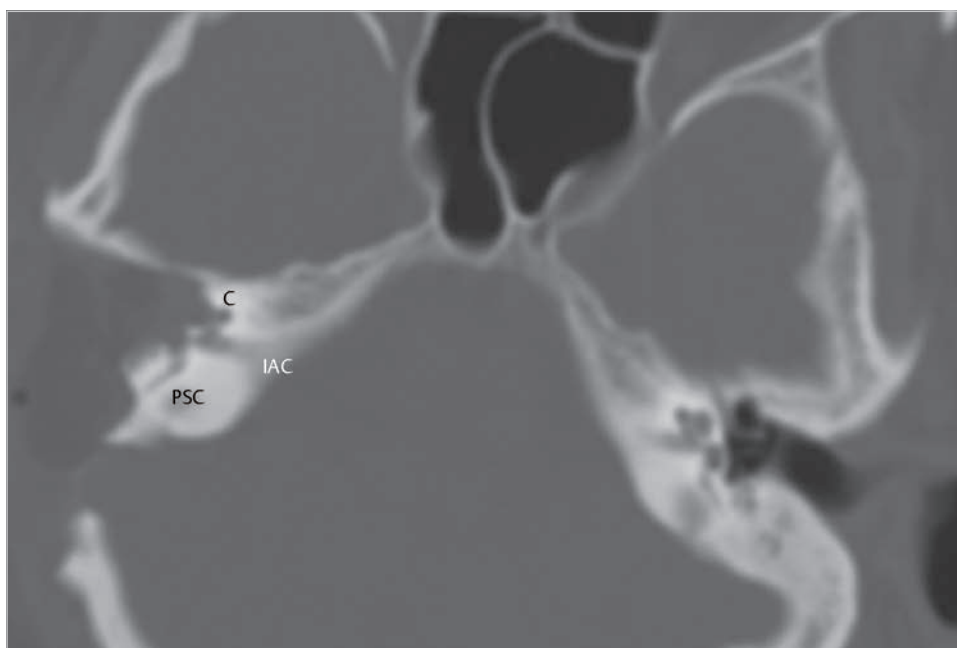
The postoperative CT shows partial removal of both cochlea and the vestibule. C, cochlea; IAC, internal auditory canal; PSC, posterior semicircular canal.
